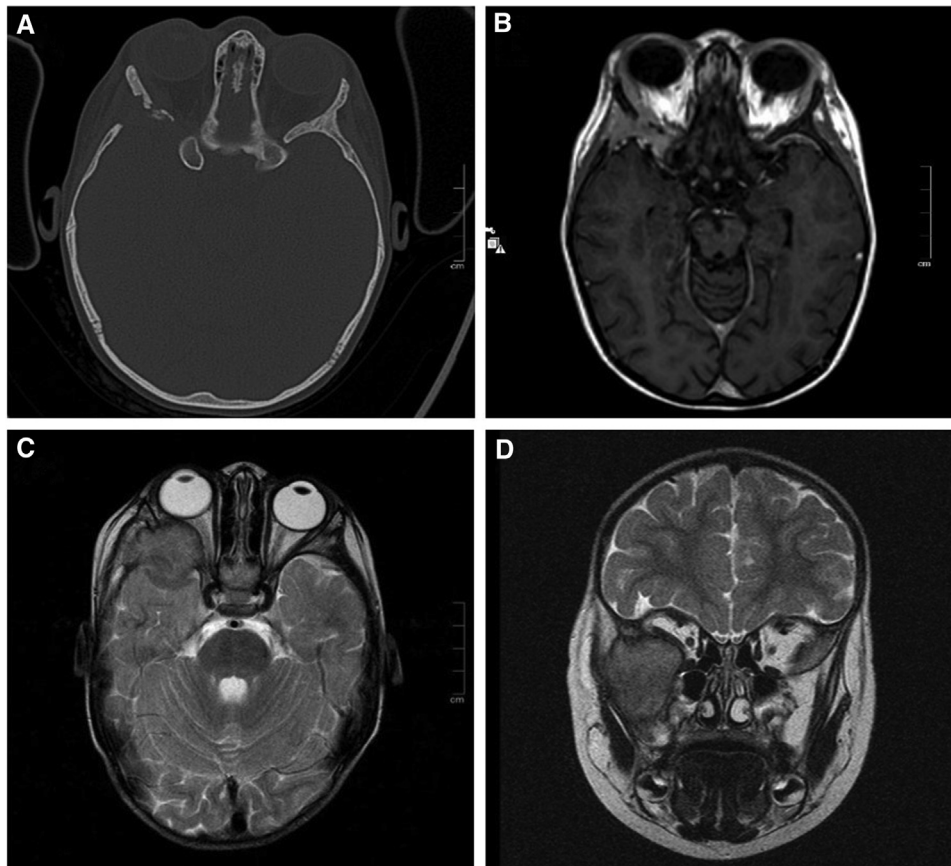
A, Axial computed tomography scan and B, T1-weighted MR images of an extraconal destructive lesion of the right lateral orbit. C, Axial and D, coronal T2-weighted images of a solid extraconal mass of the right orbit revealing displacement of the lateral rectus muscle with infiltration of the greater sphenoidal wing and the temporal muscle, clinically presenting with a proptosis.
